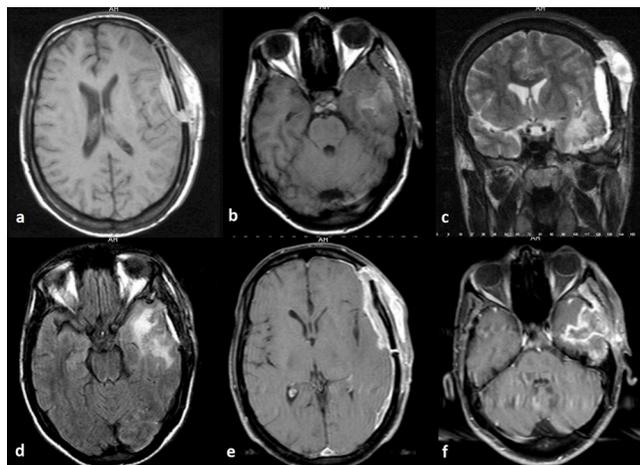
In the postoperative cranial MRI, axial T1 weighted (a,b), coronal T2 weighted (c), axial FLAIR (d) sequences reveal craniectomy defect in the left cerebral hemisphere, hyperintense subdural and cephal hematoma in the left frontotemporoparietal lobe which are communicated with a dural defect and hyperintensity in the left temporal lobe and compression of the left lateral ventricle are detected. In postcontrast T1 weighted axial (e) and coronal (f) sequences contrast enhancement is detected in the extraaxial hematoma, intraparenchymal and cephal hematoma in the left temporal lobe.
